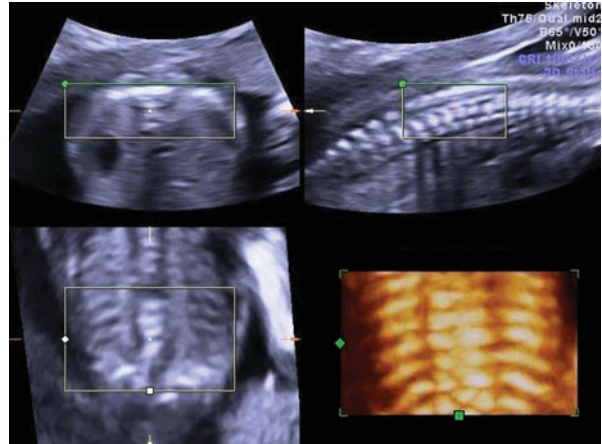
Multiplanar 3D ultrasound (US) helps to detect the level of the hemivertebra and demonstrates the severity of kyphoscoliosis.
